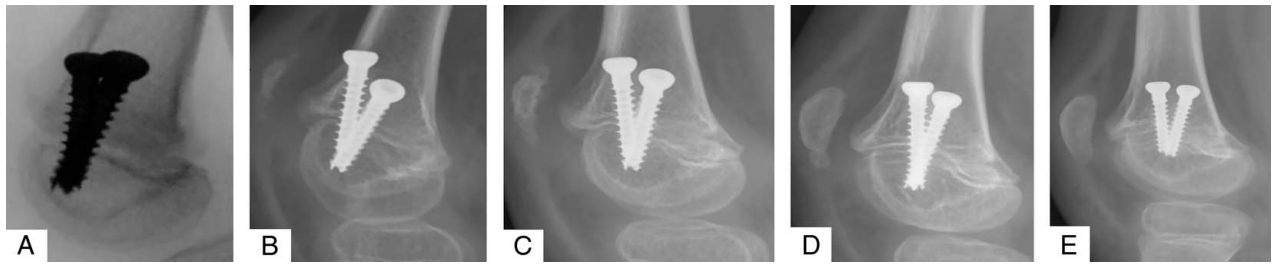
An Example of physeal angle change over 24 months including intraoperative (A), 12 months postoperative (B), and 24 months postoperative (C) radiographs.
